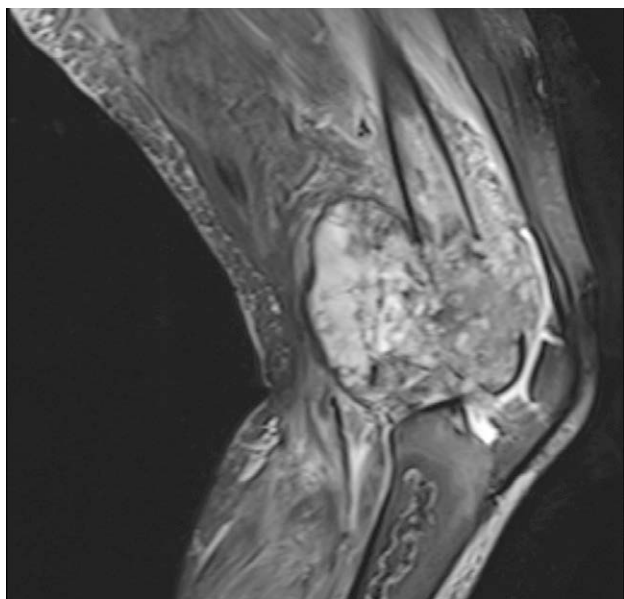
Sagittal MRI of left lower extremity revealing a distal femoral lesion with extensive soft tissue component.
